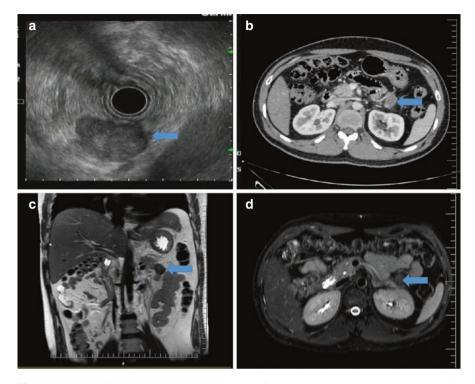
(a) Multi-detector computed tomography image showing a heterogeneous exophytic lesion in the tail of the pancreas. (b) EUS showing a 2 cm exophytic cyst seen in the distal body of the pancreas with solid debris and hyperechoic contents. T2-weighted MRI in coronal (c) and axial section (d) showing the hypointense cyst suggesting thick contents. These findings are consistent with a lymphoepithelial cyst (depicted by the blue arrow)
